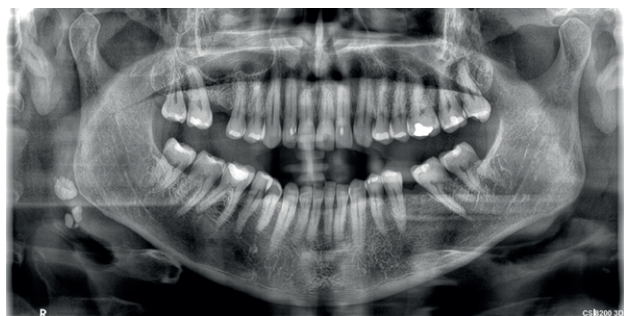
Panoramic radiograph showing calculi in the right parotid gland.
